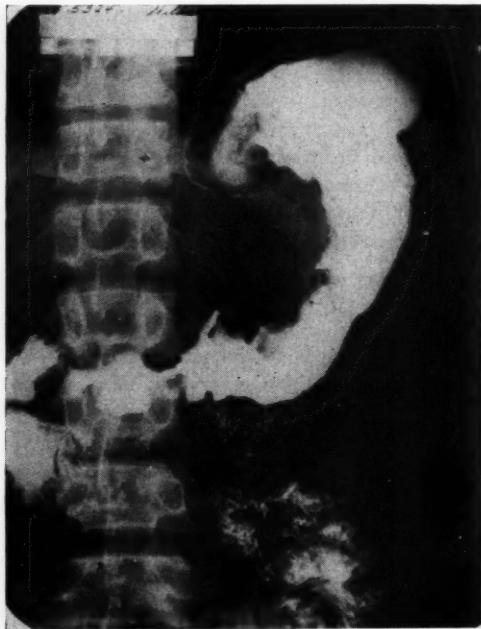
Roentgenogram showing extensive involvement of stomach by carcinoma.
